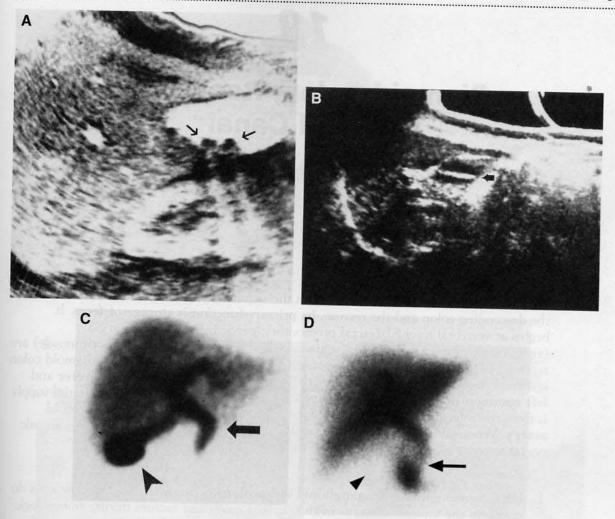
(A) Sonogram of the gallbladder. Note the two gallstones within the gallbladder (arrows). Ultrasonography usually elicits the Murphy sign, in which the patient reports pain as the operator presses on the gallbladder. (B) Sonogram of the gallbladder. Note the horizontal band of gallstones (arrow). (C) Hepatobiliary iminodiacetic acid (HIDA) scan of a healthy patient. HIDA uses the radionuclide 99mTc attached to lidocaine analogs bound to iminodiacetic acid. This compound is injected intravenously, processed by hepatocytes, and excreted into the bile. In a healthy person, filling of the liver, gallbladder, and biliary tract occurs within 60 minutes after injection. Note the filling of the liver, gallbladder (arrowhead), and common bile ducts (arrow) within 60 minutes after injection. (D) HIDA scan of a patient with acute cholecystitis. Note that the gallbladder (arrowhead) has not filled 90 minutes after injection, which is diagnostic of a blockage. However, the liver and common bile duct (arrow) are filled. Because most gallstones are composed of cholesterol (and, therefore, are radiolucent), plain abdominal radiographs often are of little value. Therefore, ultrasonography and HIDA are the methods of choice for diagnosis. (A-C reprinted with permission from Freedman M: Clinical Imaging: An Introduction to the Role of Imaging in Clinical Practice. New York, Churchill Livingstone, 1988, pp 368, 369; A and B courtesy of R. Sanders, MD; D reprinted with permission from Levy RC, Hawkins H, Barsan WG: Radiology in Emergency Medicine. St. Louis, CV Mosby, 1986, p 234.)
